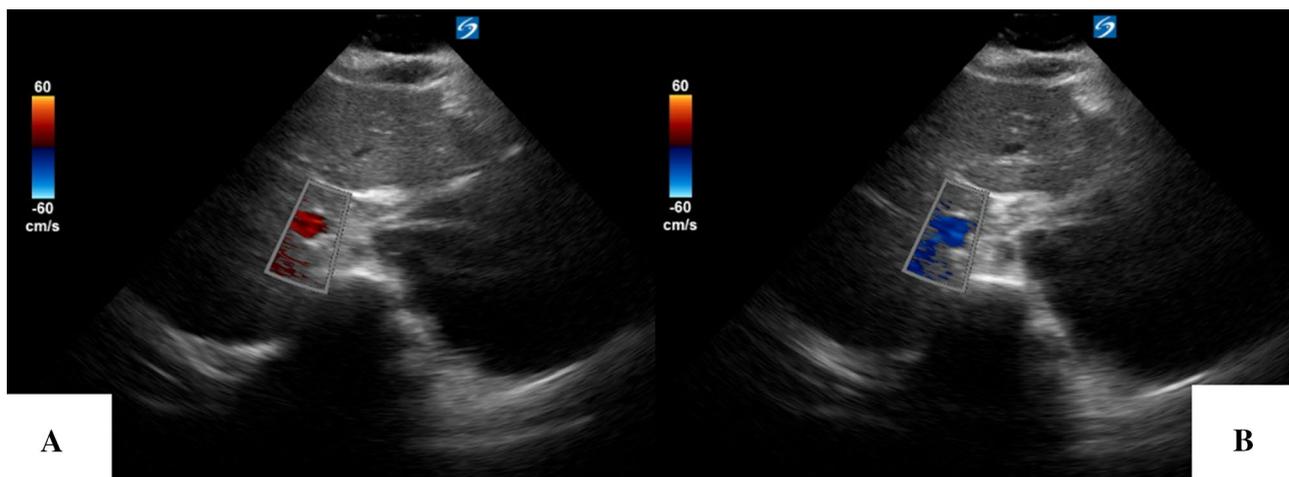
Transverse IVC view with color flow doppler over the intrahepatic IVC. Without changing the probe position or orientation, the reversal of flow is indicated by change from red to blue
